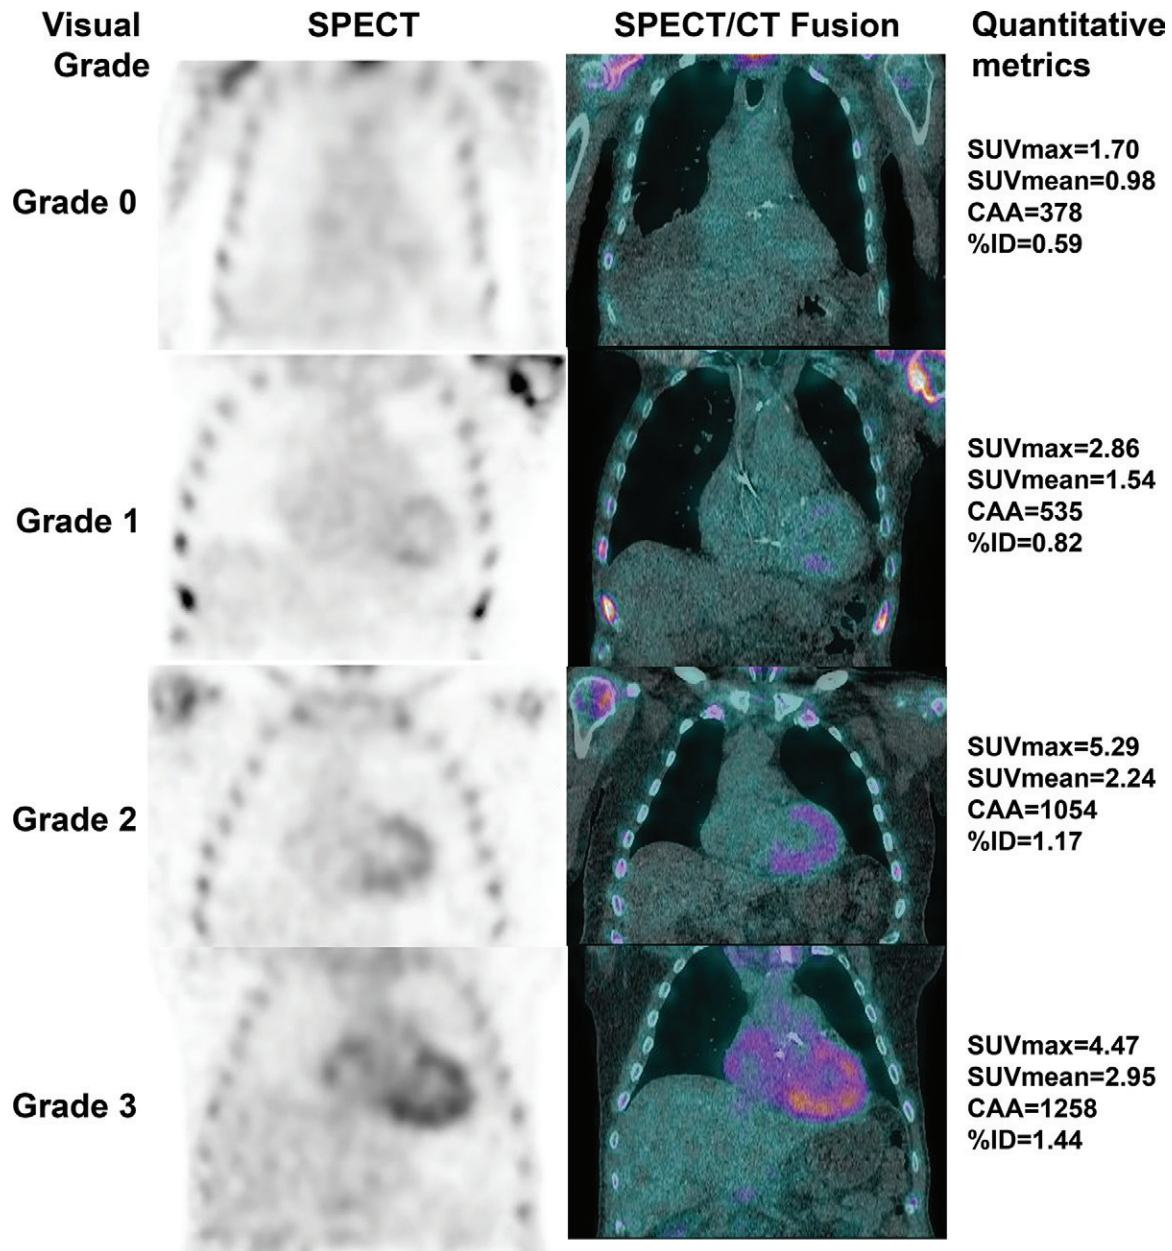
Visual grading and quantitative metrics from technetium 99m pyrophosphate SPECT/CT images. The left column shows attenuation-corrected SPECT images with visual grading labels; the right column shows SPECT/CT fusion images with corresponding maximum standardized uptake value (SUVmax), mean standardized uptake value (SUVmean), cardiac amyloid activity (CAA), and percentage injected dose (%ID) for each image.
